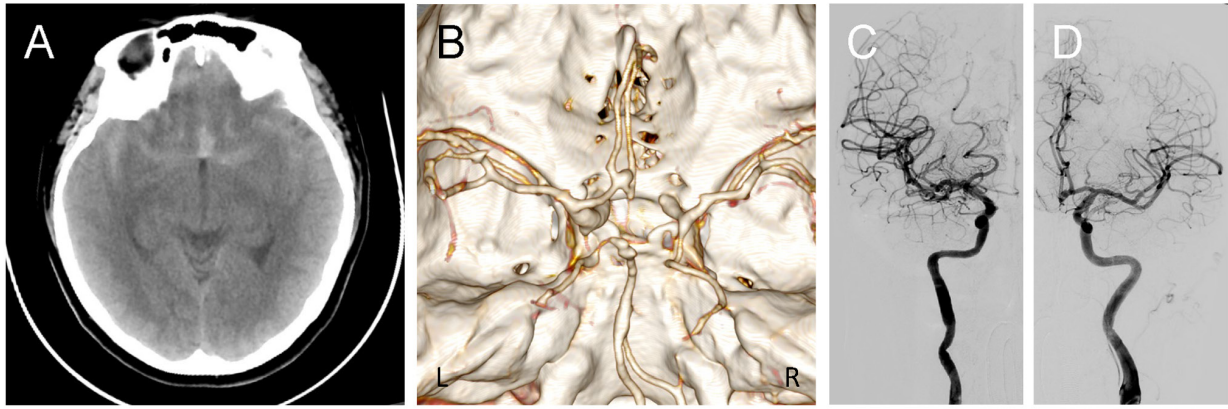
(A) Non-contrast head CT. (B) CT angiography. (C) Right internal carotid artery DSA revealing a hypoplastic right A1 segment of the anterior cerebral artery. (D) Left internal carotid artery DSA showing a dominant left A1 segment, with visualization of both pericallosal arteries and an anterior communicating artery aneurysm. CT, computed tomography; DSA, digital subtraction angiography.
